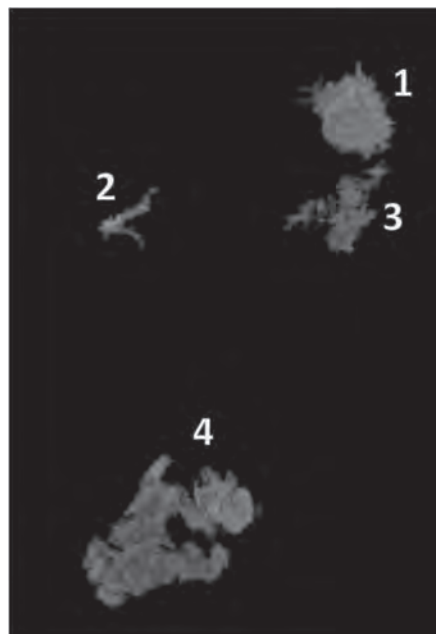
Distribution of water in the GI tract of a healthy volunteer under fasting conditions obtained by magnetic resonance imaging (frontal view). In this example gastrointestinal water is present in the stomach (1: 27 mL) and three “water pockets” that are located in the duodenum (2: 3 mL), in the proximal jejunum (3: 11 mL) and the terminal ileum (74 mL).
